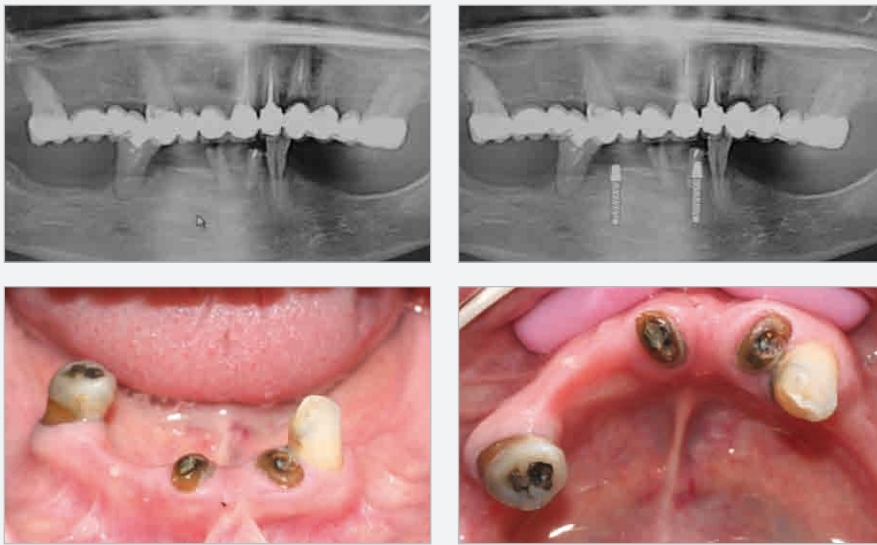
Presurgical X-ray, treatment planning on OPT and clinical view at first visit.
